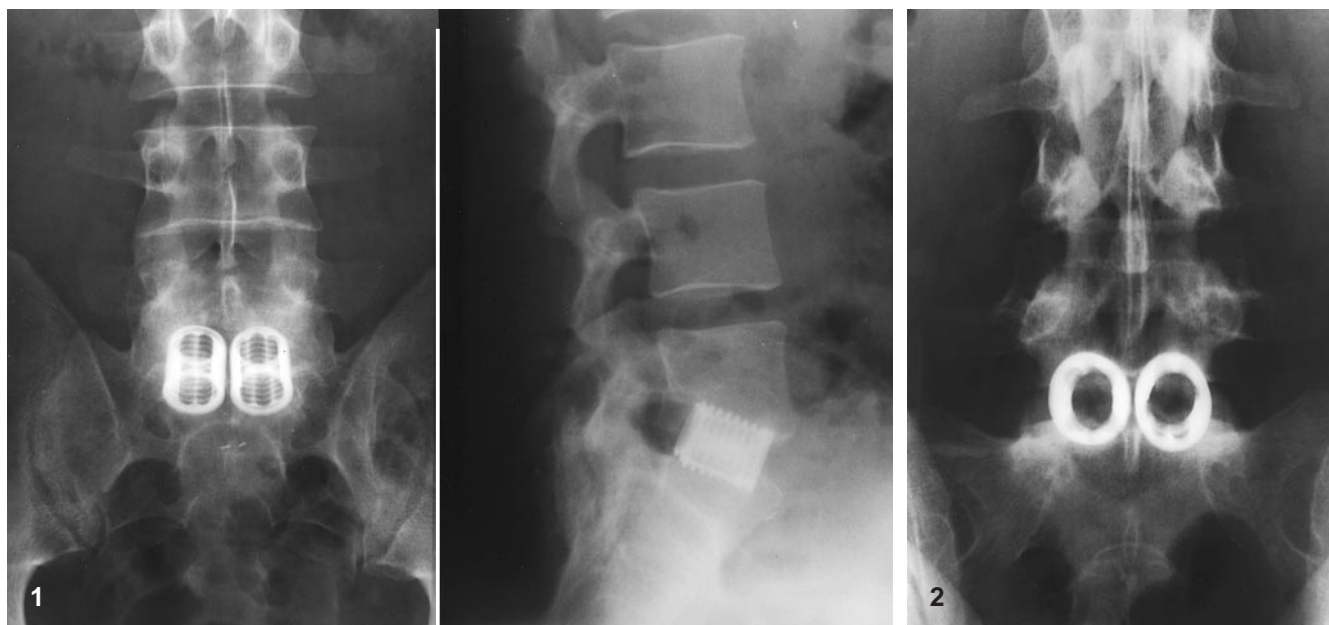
Examples of the postoperative radiographs showing the positioning of the threaded fusion cages in an anterior-posterior (*left*) and lateral view
